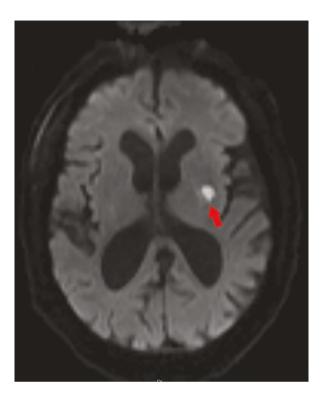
Brain MRI with acute left basal ganglia lacunar infarct
